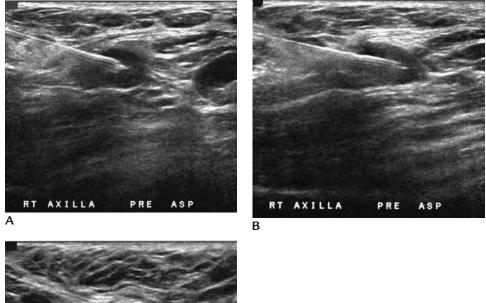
Fine needle aspiration of axillary lymph node. (A and B) With the needle in the mass, suction is applied and the needle is moved methodically from one edge of the mass to the other under ultrasound guidance. Several methodical, slow excursions are done with minor variations in the angle of the needle all under ultrasound guidance. Notice the change in needle position between images. (C) Orthogonal ultrasound image is done to confirm appropriate needle (*arrow*) placement in the center of the lesion. Needle is imaged in cross-section surrounded by the lesion being sampled.
